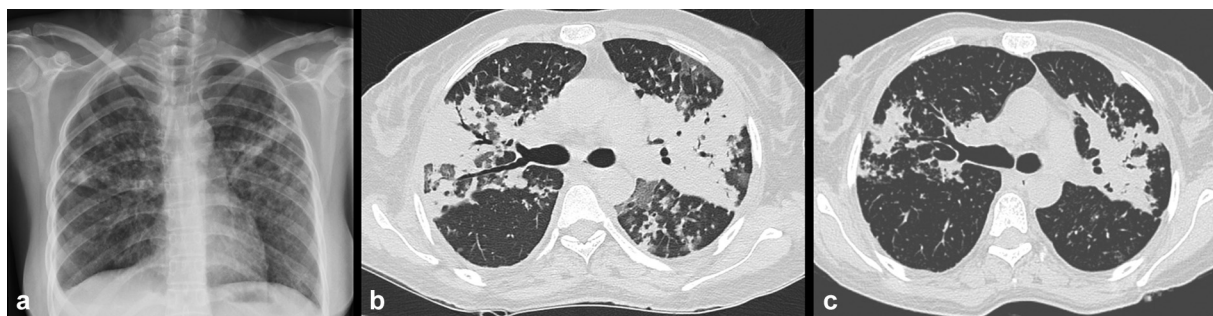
Radiological findings in the patient. At the time of diagnosis, the chest radiograph showed mild right pleural effusion (1a), while the computerised tomography images (1b) revealed bilateral parenchymal involvement with patchy consolidation. Imaging done 4 weeks after (1c) treatment with ATT and cotrimoxazole showed radiological clearance.
